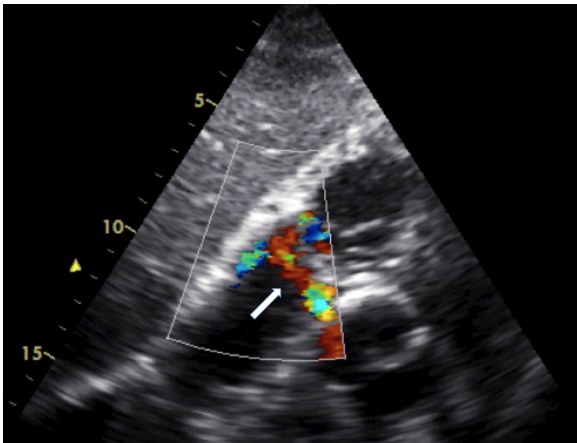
Transthoracic echocardiography. Color Doppler revealed the newly detected aorto-right atrial shunt (arrow).
